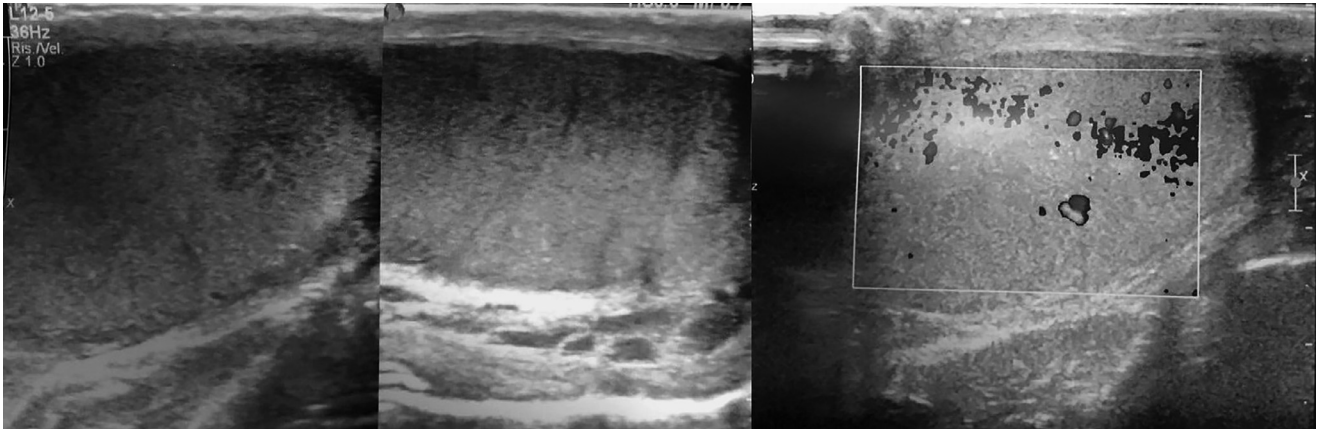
Testicular integrity at ultrasound (US) scan. Tunica albuginea covering the right testis is not interrupted. Color Doppler US shows normal testicular vascularity.
